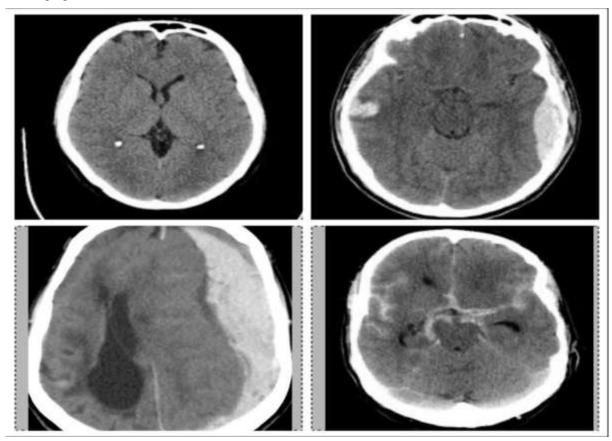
CT BRAIN IMAGING SHOWING NORMAL, EDH, SDH AND SAH RESPECTIVELY. BACKGROUND OF THE STUDY:
